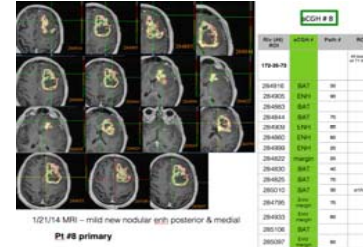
MRI images of a left frontal lobe GBM with the various biopsy locations depicted by the intersection of the green lines. The table: ROI (regions of interest) column are the biopsy locations coded to correlate with the MRI that will be sent to ASU to incorporate into their machine learning algorithm, aCGH column identifies if the sample is BAT or enh, and the path column displays percent tumor of the sample.
